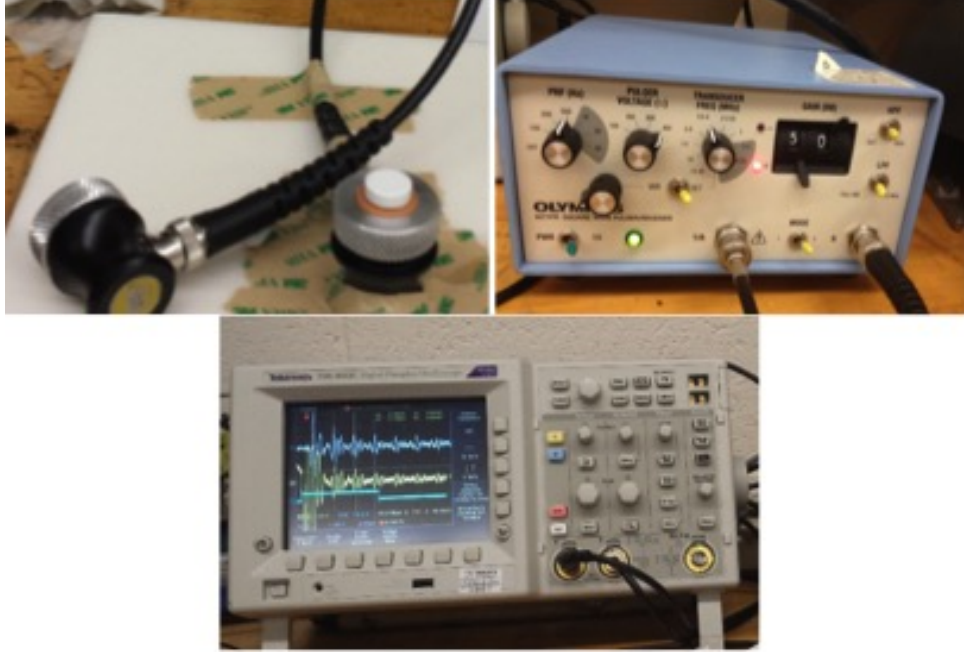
The acoustic experimental setup showing ultrasound transducers, pulser/receiver unit, and a digitizing oscilloscope.
